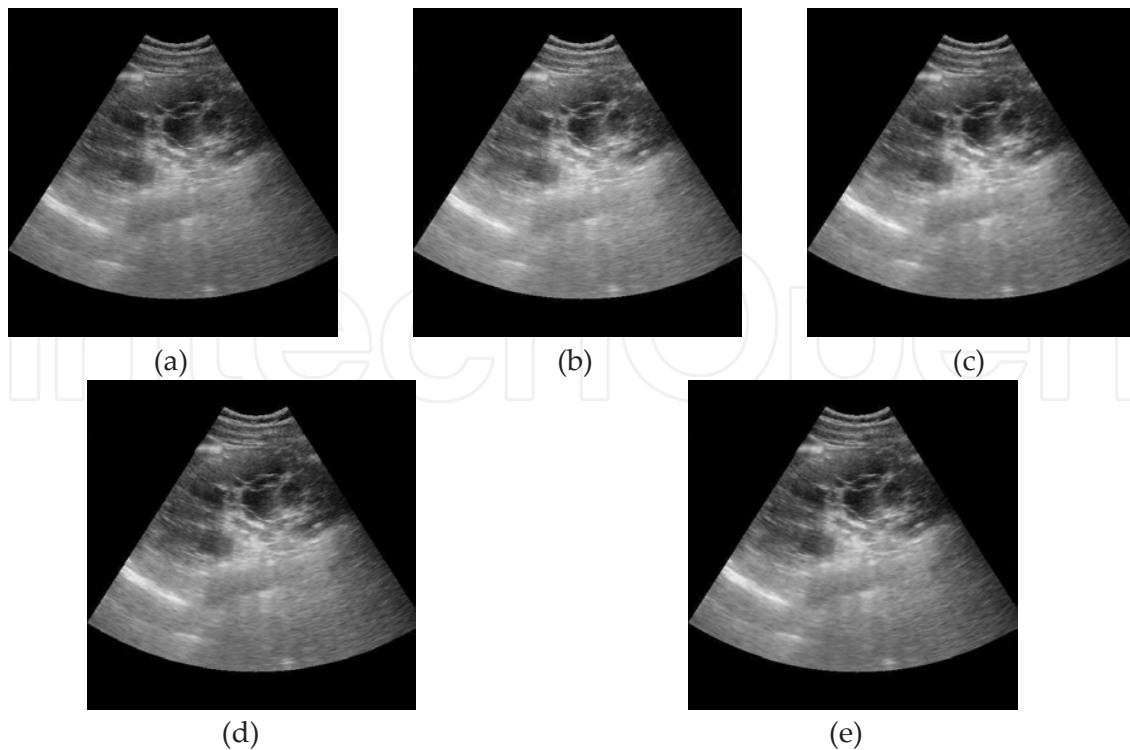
a) Original ultrasound image. (b) Despeckled image using wavelet transform using subband Bayes soft thresholding (level 3). (c) Despeckled image using contourlet transform using soft thresholding. (d) Despeckled image using contourlet transform using hard thresholding. (e) Despeckled image using contourlet transform using semi soft thresholding.
